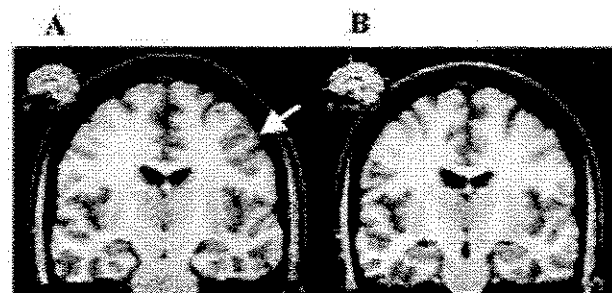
Coronal T1-weighted images of a normal subject show the effect of the change in orientation of the planes of section. (A) Area of artifactual cortical thickening (arrow) due to volume averaging. (B) The artifact disappears in a different orientation of the plane of section, as shown by the scout sagittal image in the upper left-hand corner.
